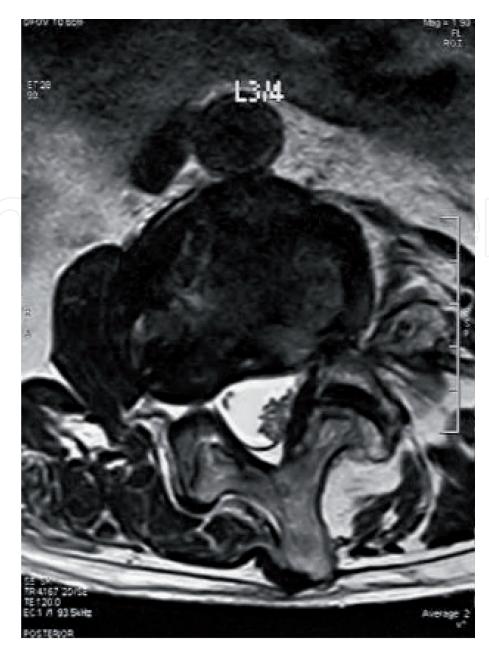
Lumbar multifidus atrophy. From the MRI, it is evident that there was marked asymmetric lumbar multifidus atrophy at the level of L3/L4. The fatty infiltration area in the left multifidus was significantly larger than that in the right multifidus.
